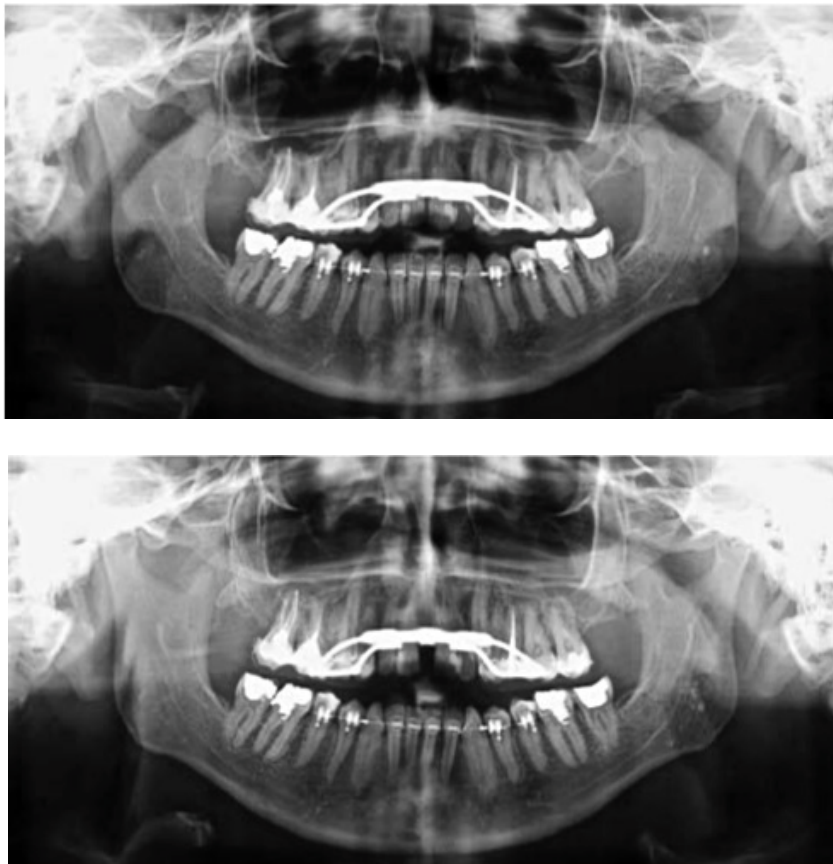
Panoramic X-Ray before SARPE (top) and after SARPE (bottom) (19)
